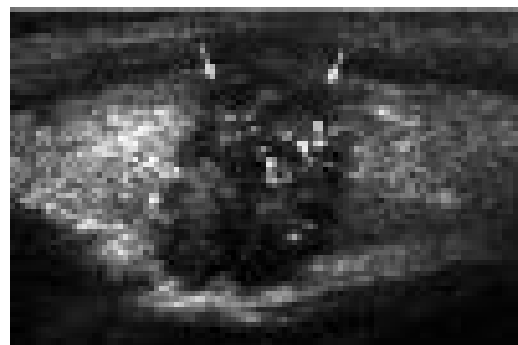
Longitudinal grey scale sonogram shows characteristic punctate calcifications within an ill-defined solid hypoechoic thyroid nodule which is highly suggestive of papillary carcinoma.
